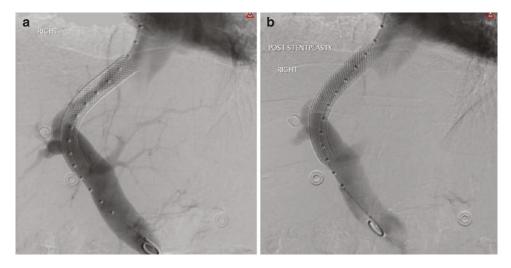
(a) A 56-year-old male with alcoholic cirrhosis and refractory ascites. When the patient initially had his TIPS placed, his ascites resolved; however 6 months later, he again developed ascites which prompted a Doppler ultrasound demonstrating elevated velocities within the TIPS. Venography performed (left) demonstrates severe narrowing of the parenchymal component of the stent. The stenosis did not respond to simple balloon angioplasty. (b) Venographic images following the deployment of a Viabahn-covered stent within the parenchymal tract and complete resolution of the stenosis and revision of the TIPS
